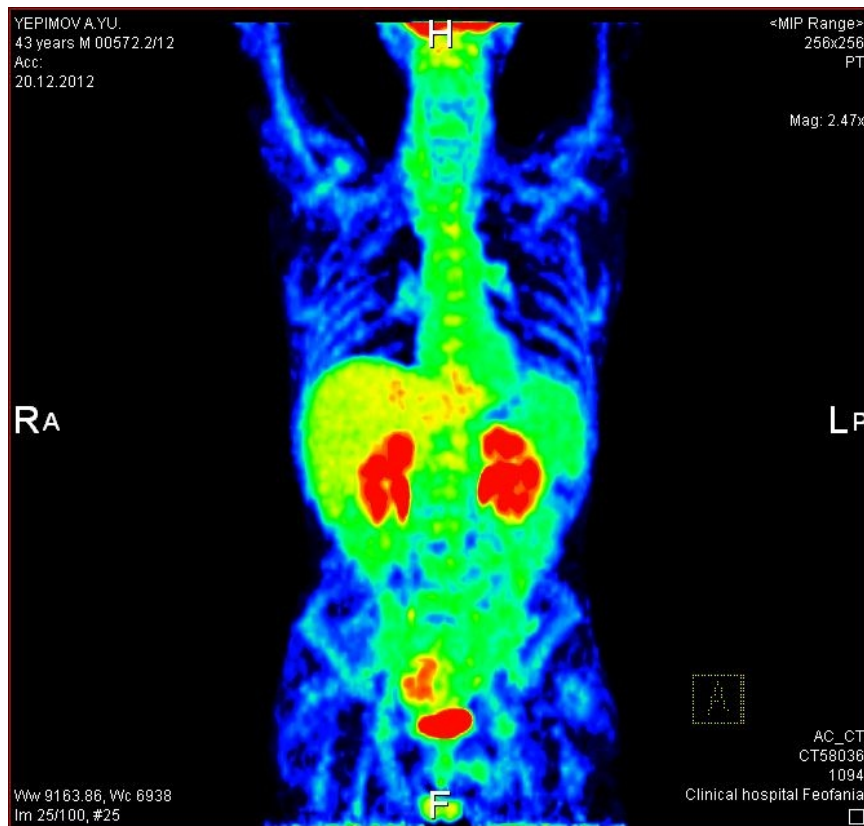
The results of PET-CT study after 3 cycles of chemotherapy in a patient A.
